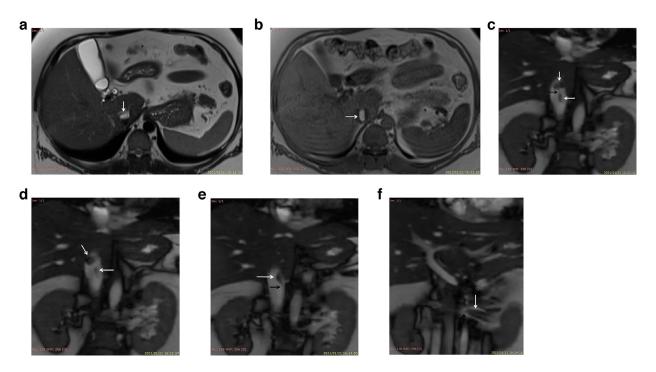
Magnetic resonance (MR) images obtained 25 days after initial contrast-enhanced computed tomography. Axial T2 MR image (a) demonstrates homogeneous hyperintense oval mass in the IVC (white arrow). Axial T1 MR image (b) demonstrates homogeneous hyperintense oval mass in the IVC (white arrow). However, the mass has moved from its position when the axial T2 image was taken. Cine-mode coronal MR images (c, d) show movement of the upper IVC mass (white arrows). The two IVC masses appear connected to one another by a cordlike structure (black arrow). Cine-mode coronal MR images (e, f) show cordlike structures (black arrows) attached to the lower IVC mass and the left renal vein mass (white arrows).
